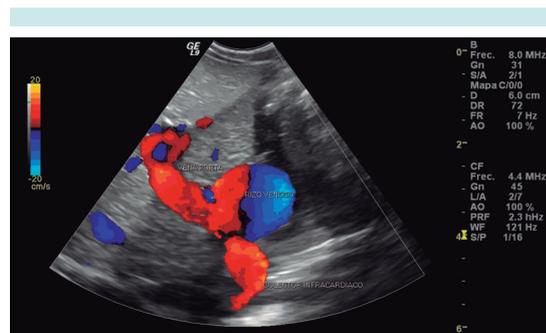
Abdominal ultrasound with presence of aneurismatic dilation of the collector before connecting to the portal vein.
